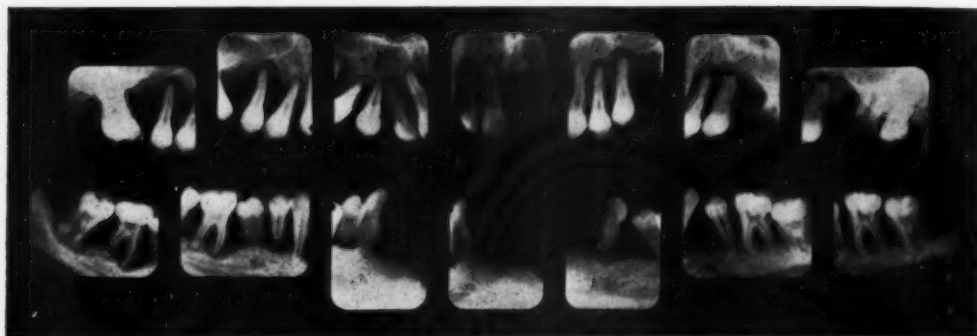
Diabetes (juvenile), in boy eighteen years of age. Dental roentgenogram reveals almost total destruction of alveolar bone as a result of periodontitis. Many of the teeth are supported by soft tissue only, and several of them have been sloughed. (Reproduced, with permission, from Stafne, E. C.: Dental Roentgenologic Aspects of Systemic Disease. *J. Am. Dent. A.* 40: 265-283, March 1950.)
